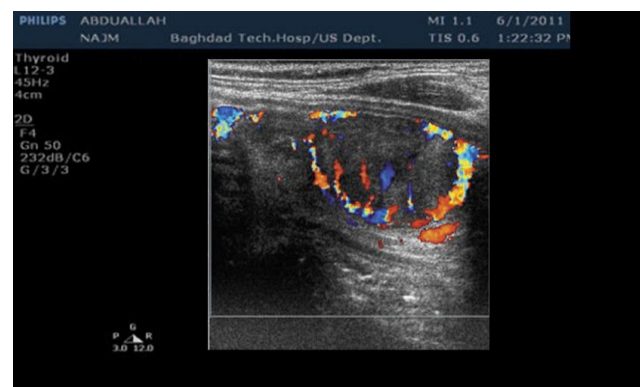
Showing peripheral vascularity in a thyroid nodule on Color Doppler
